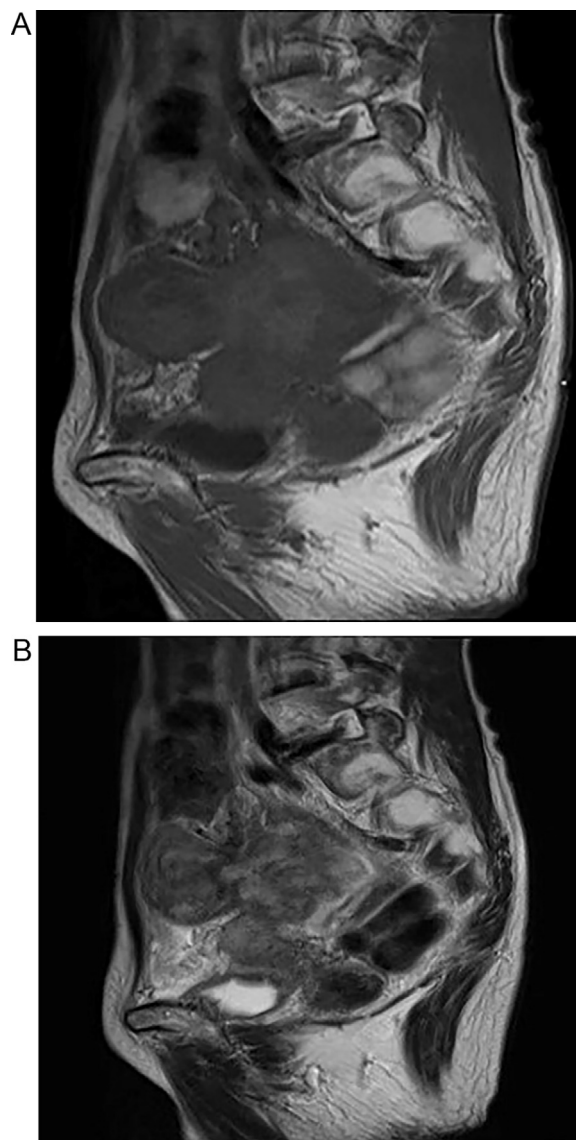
The mass was seen with a low signal intensity on T1-weighted images (2A) and with an inhomogeneous signal intensity on T2-weighted images (2B). The boundary between the tumor and the uterus was unclear.
